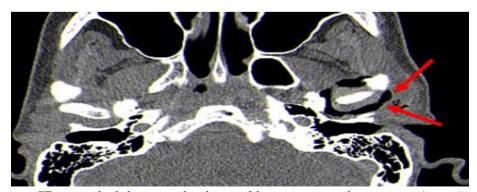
Post infiltration CT scan to check the correct distribution of the gas mixture in the joint cavity (arrows).
